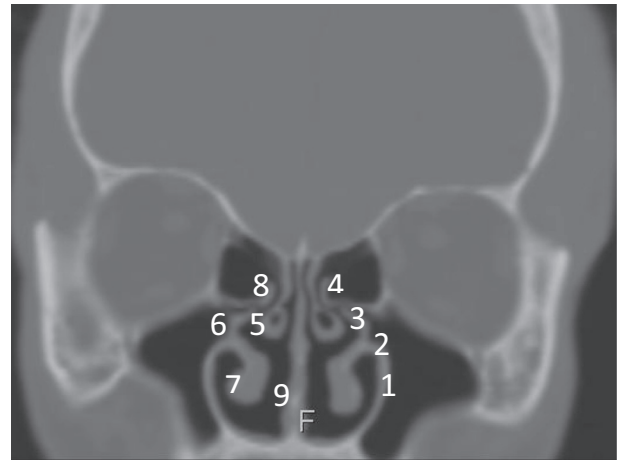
A coronal CT image demonstrating the osteomeatal complex and the nasal cavity. (1) Maxillary sinus, (2) maxillary ostium, (3) infundibulum, (4) ethmoidal bulla, (5) middle nasal turbinate, (6) uncinate process, (7) inferior nasal turbinate, (8) hiatus semilunaris, (9) nasal septum.
